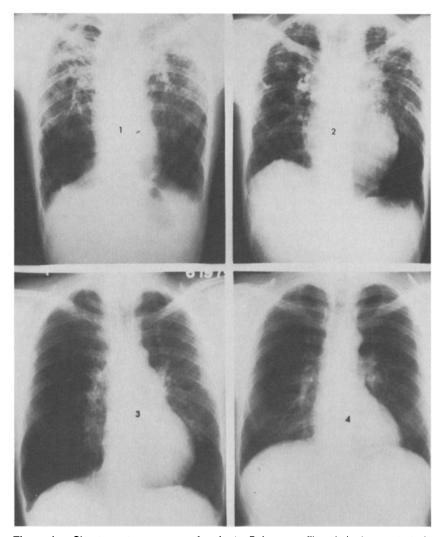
Chest roentgenograms of patients. Pulmonary fibrosis is demonstrated in Cases 1, 2 and 3. In Case 4 the film shows no abnormalities.
